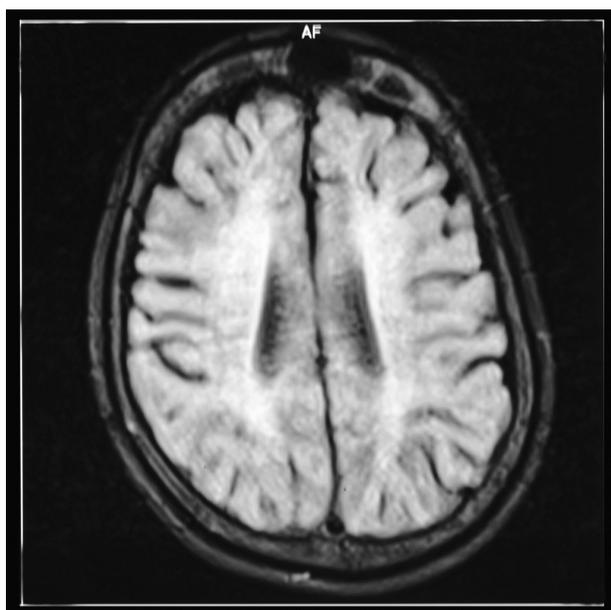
MRI T2 flair showing leucodystrophy
